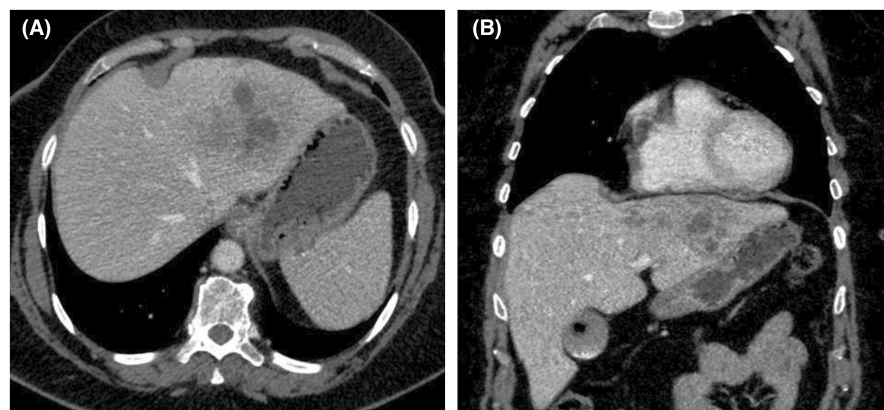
The hepatic abscesses by contrast-enhanced computed tomography scan in the axial plane (A) and coronal plane (B). An multiloculated abscess of total 8 cm diameter was depicted in the left liver lobe.
